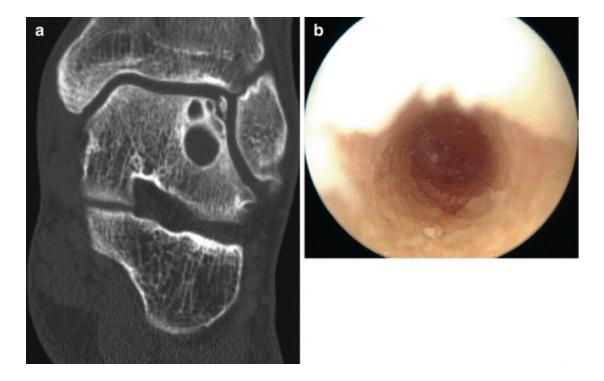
Coronal reformatted CT image of the left ankle (a) shows subchondral talar cyst. Intra-osseous view of a talar cyst during ankle arthroscopy (b)
